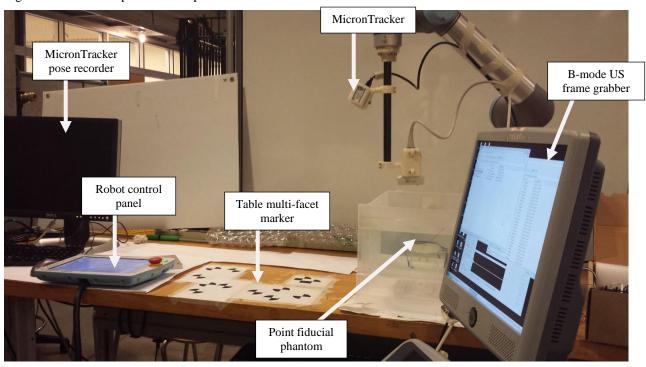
Robot-held ultrasound calibration setup
